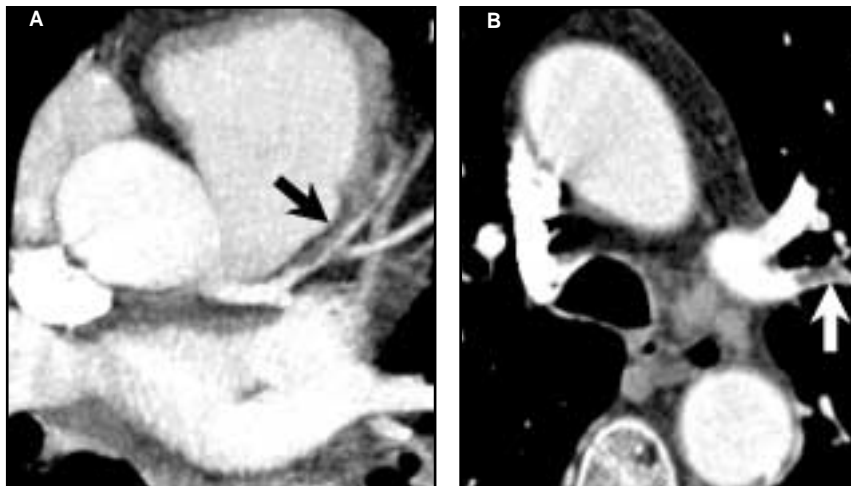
(A) In a patient with atypical chest pain, CTA detects a thrombus (arrow) in the left anterior descending coronary artery. (B) This application is similar to the established role of CTA in the evaluation of pulmonary embolism (arrow).
